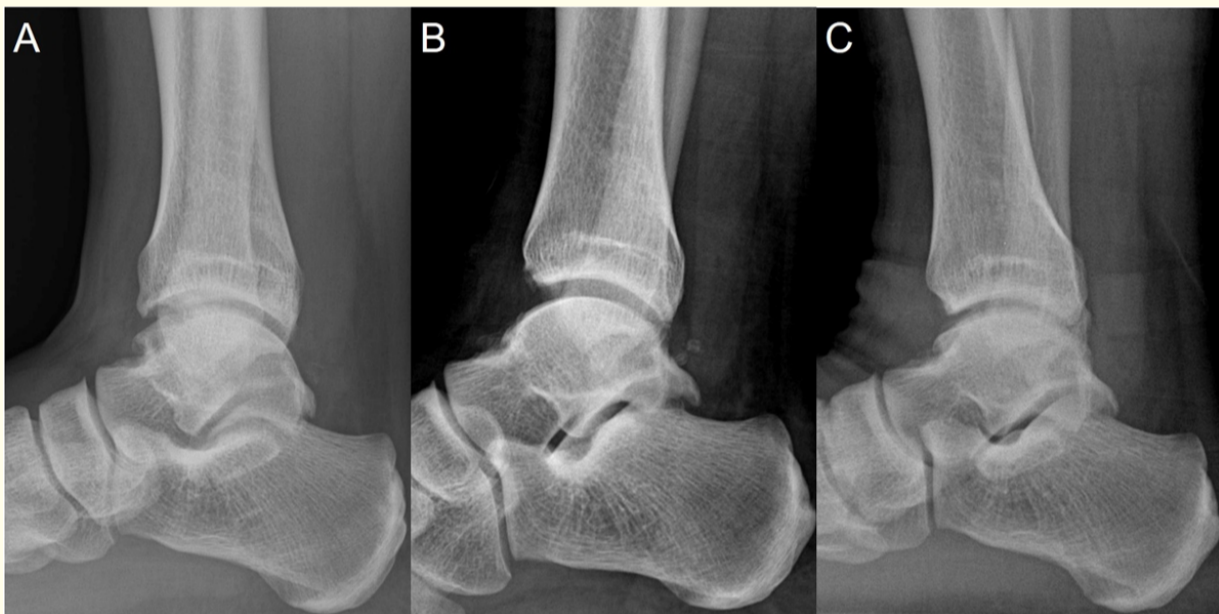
Serial weight-bearing lateral radiographs in a 47-year old-male patient. (A) Pre-operative radiograph showing the bony spur on anterior tibial plafond. (B) Postoperative radiograph revealing disappearance of the bony spur after resection of the lesion during the primary arthroscopic treatment. (C) Final follow-up radiograph showing no bony spur recurrence at 2 years after operation.
